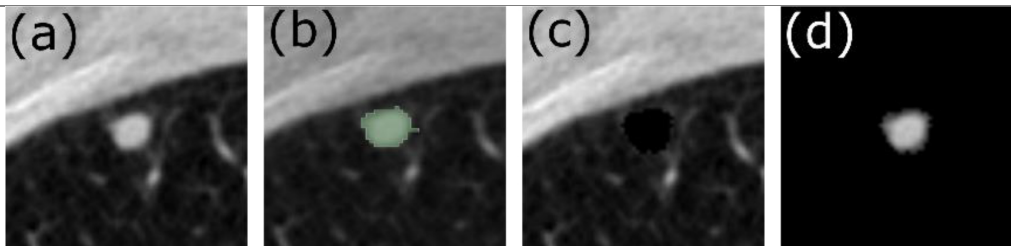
Axial slice from a Low Dose Computed Tomography (LDCT) image showing the (a) the original LDCT scan, (b) the segmented tumor map, (c) the parenchyma-only image, (d) the tumor-only image.
